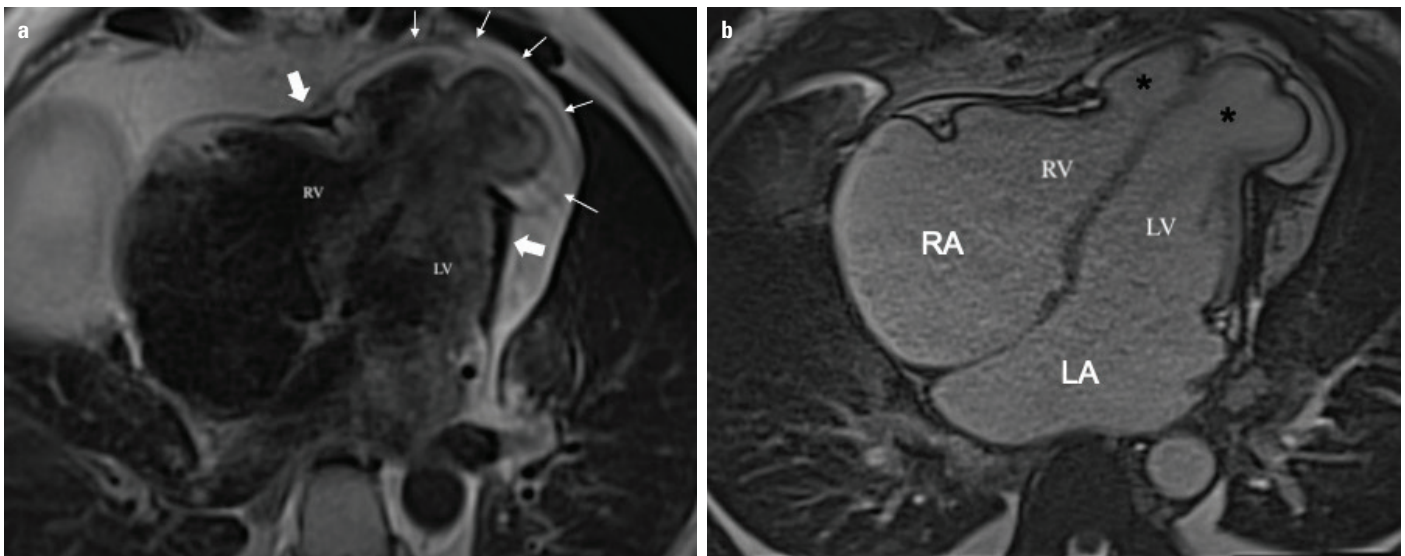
(a) Transverse T1-weighted CMR image correlating with the CT findings and better delineating the spared apical pericardium (small arrows). LV - left ventricle; RV - right ventricle. (b) Cine image intersecting of the 4-chamber plane demonstrating biventricular apical ballooning and biatrial dilatation. No wall motion abnormality was noted, and no fibrosis was detected on late gadolinium enhanced images (not shown)
